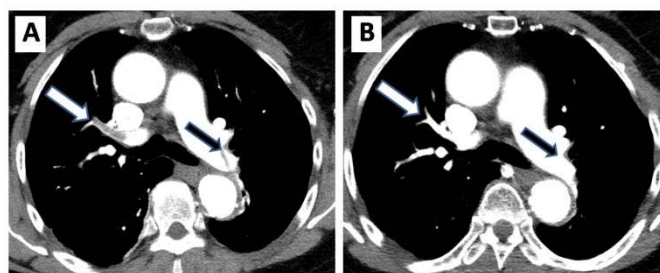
Thoracic CT images showing the acute pulmonary embolism in the right upper segmental pulmonary artery (white arrow in A) with left main pulmonary artery (black arrow in A) and dissolution of blood clots at end of the treatment (arrows in B).
